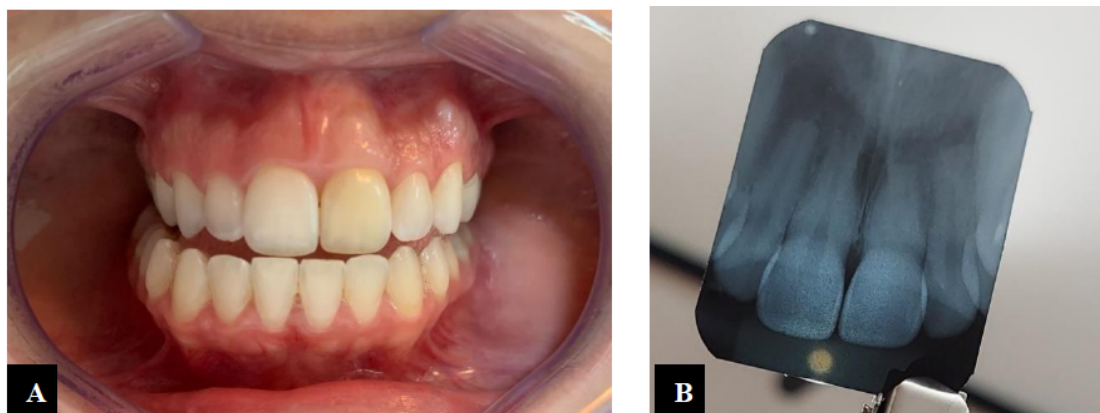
A) Intraoral clinical examination, element 21 darkened. B) Initial radiograph, without canal lumen visualization.
